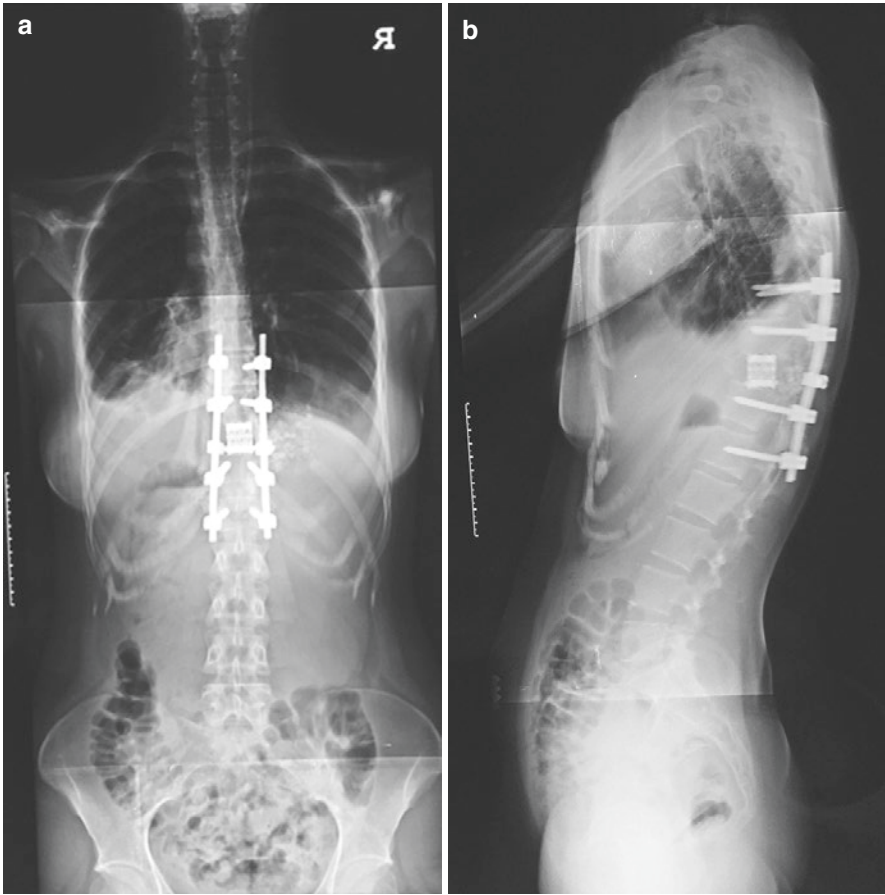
A-P (a) and lateral (b) X-ray view after reconstruction of the vertebral column with a mesh cage and posterior pedicle screw fixation
